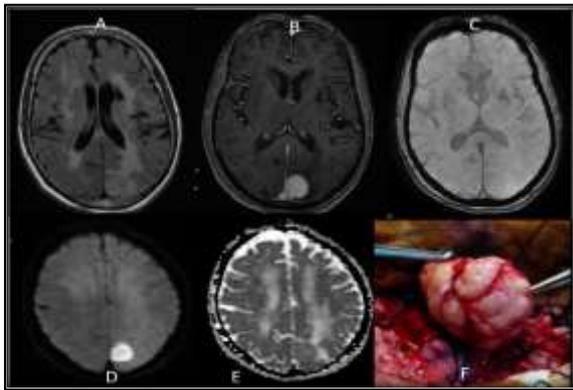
(A) Axial FLAIR image shows a left posterior falxine extra-axial lesion, which appears hyperintense on FLAIR. Mild surrounding white matter tract edema is noted (level1) B) On post-contrast, axial T1WI homogenous enhancement is noted. (C) Axial SWI images show no areas of blooming within. (D) On DWI, significant diffusion restriction is noted; (E) On ADC maps, the average tumoral ADC was found to be $631 \times 10^{-6} \text{ mm}^2/\text{sec}$, and NADC calculated was found to be 1.08. (F) The tumor was found to be intermediate in consistency intra- operatively.
